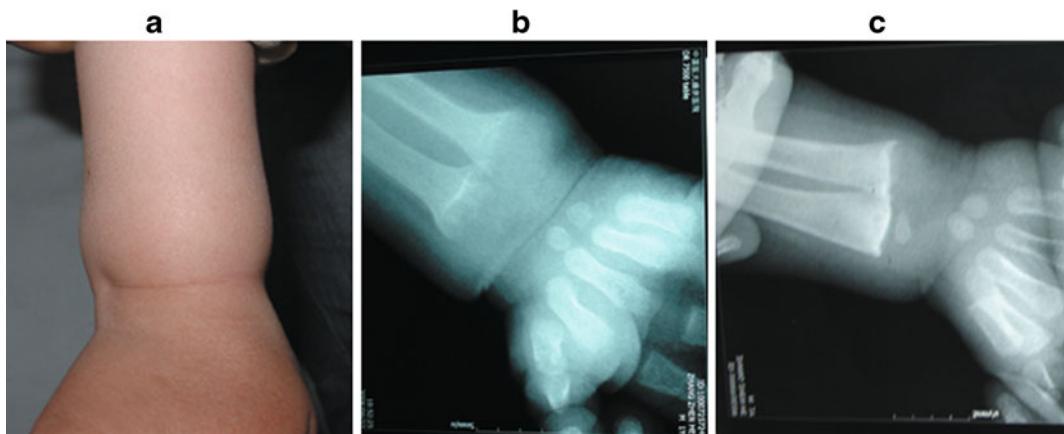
Photographs and radiographs of the Chinese VDDR-1 patient. (a) Photograph showing enlargement of the wrist, like wearing a bracelet. (b) Wrist radiograph before treatment presenting the vanishing of the zone of provisional calcification in distal metaphysis, rarefaction of bone trabecula and thinness of the cortical bone in the left ulna and radius. (c) Wrist radiograph after treatment showing reoccurrence of the zone of provisional calcification in distal metaphysis, the improvement of bone trabecula and thickening of the cortical bone.
